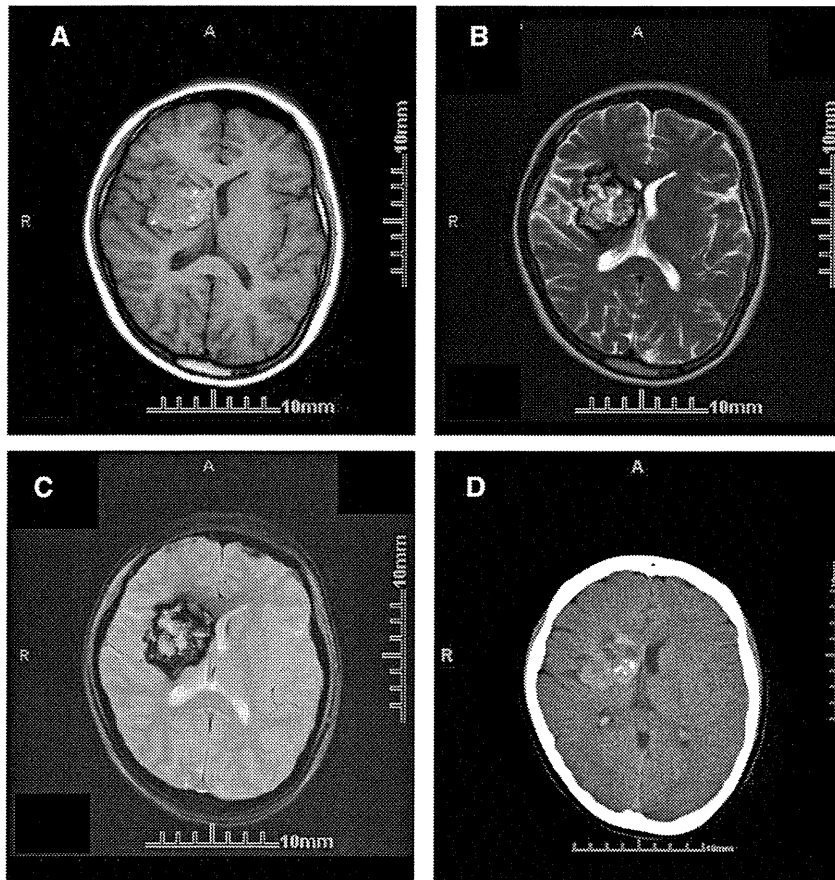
MRI and CT images in a patient with a giant CH. (A) T1-weighted MRI. (B) T2-weighted MRI. (C) T2*-weighted MRI. (D) CT.
